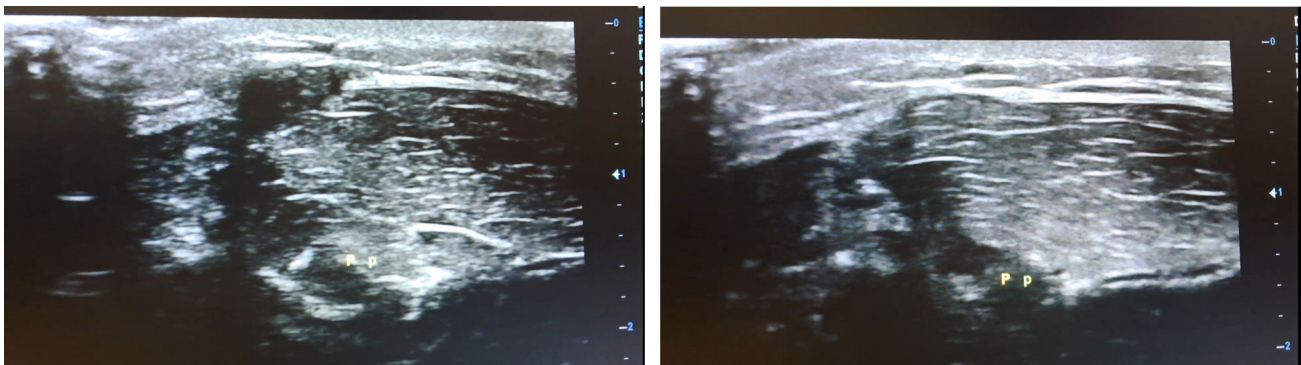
Ultrasound images. Right side, muscles at rest; left side, muscles contracted.
